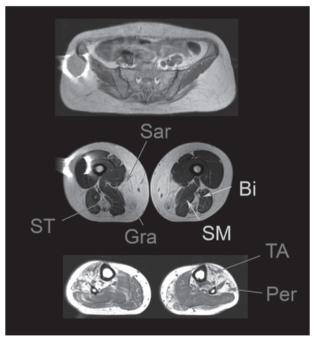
Muscle MRI of a patient with mutation is the DES gene. Muscle MRI shows a preferential involvement of semitendinosus (ST), sartorius (Sar) and gracillis (Gra) muscles, while in contrast semimembranosus (SM) and biceps (Bi) are not involved. In the legs, there is an involvement of tibialis anterior (TA) and peroneus muscles (Per). Courtesy of Dr. Giorgio Tasca.
